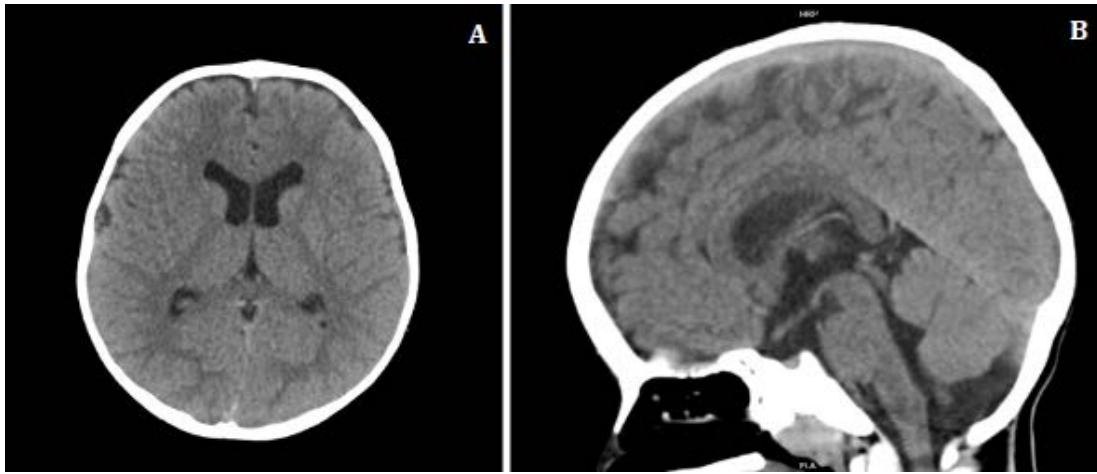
2-year-old male with convulsions. FINDINGS: Axial (A) and Sagittal (B) Cranial Computed Tomography Scan with that shows adequate differentiation between gray and white substance, no supratentorial parenchymal alterations defined, ventricular system of normal morphology, central middle line, no extra-axial collections defined, normal-looking posterior cavity. TECHNIQUE: Multidetector tomograph simple axial acquisitions from the base of the skull to the vertex and subsequent multiplanar reconstructions. Source: Patient’s medical chart, 2022.
